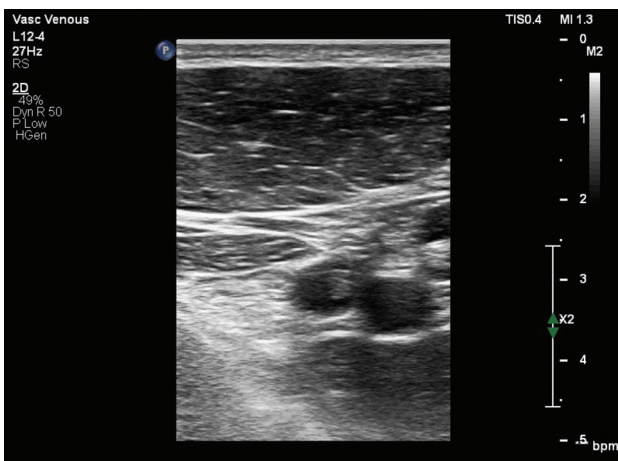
Venous ultrasound, residual thrombus.
